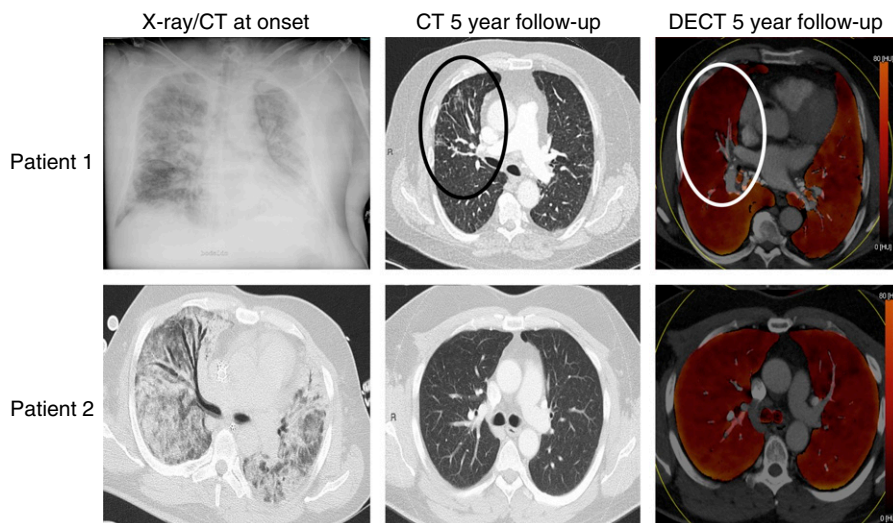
(Top row) Patient 1: 58-year-old man with influenza A H1N1–induced acute respiratory distress syndrome (ARDS). (Left) A supine conventional X-ray on admission with bilateral opacifications. No computed tomography (CT) was performed. (Middle) Five-year follow-up CT, in which the axial morphological image reveals signs of pulmonary injury with traction bronchiectasis and linear strands in the anterior parts of the right upper lobe, marked with black oval. (Right) Axial color-coded perfusion map (DECT) with deficits corresponding with the morphological findings marked with a white circle. (Bottom row) Patient 2: 40-year-old man, in whom a combination of cytokine release after intensive chemotherapy because of acute myeloid leukemia, infection, and massive transfusions most probably caused the ARDS. (Left) Signs of ARDS on CT at admission with bilateral ground glass opacities and consolidations without pleural fluid. (Middle) Axial section demonstrating no pathological findings on the five-year follow-up CT. (Right) Normal-appearing axial color-coded perfusion map (DECT). DECT = dual-energy computed tomography.
